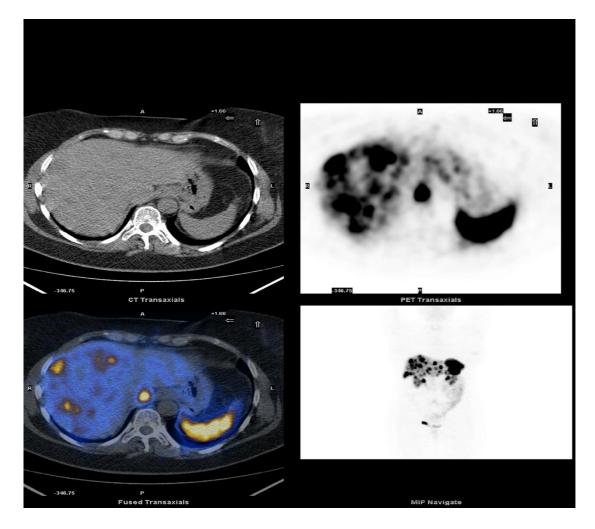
<sup>68</sup>Gallium PET/CT of a pNET with liver metastases
